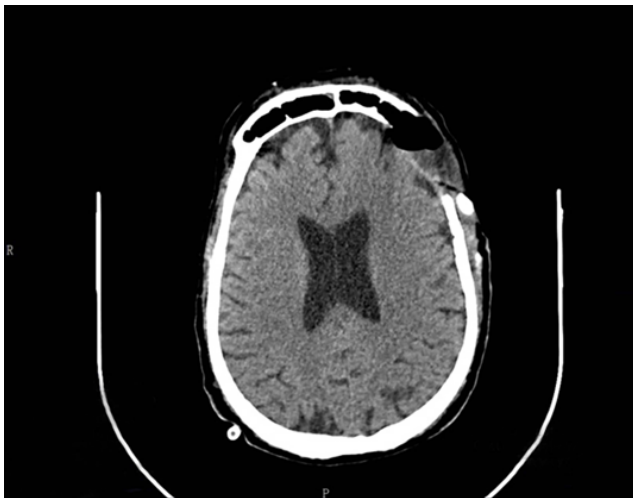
Repeat MRI of the brain showing no increase in necrotic bone, but a localised collection
